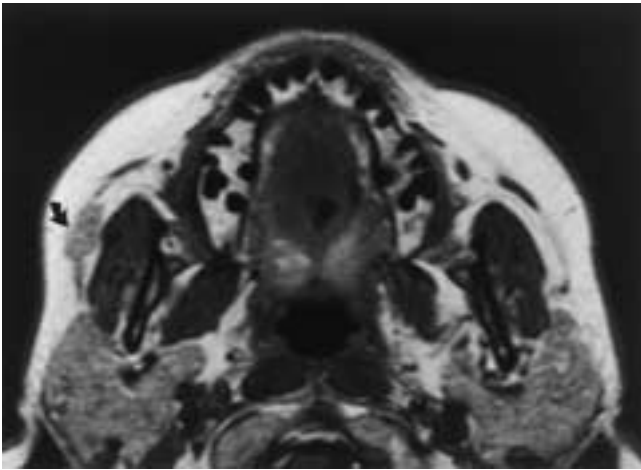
Accessory parotid tissue. Axial T1-weighted MR image. Unilateral accessory parotid tissue (*arrow*) is demonstrated overlying the masseter muscle. This tissue has the same signal intensity as tissue in the main parotid gland.
